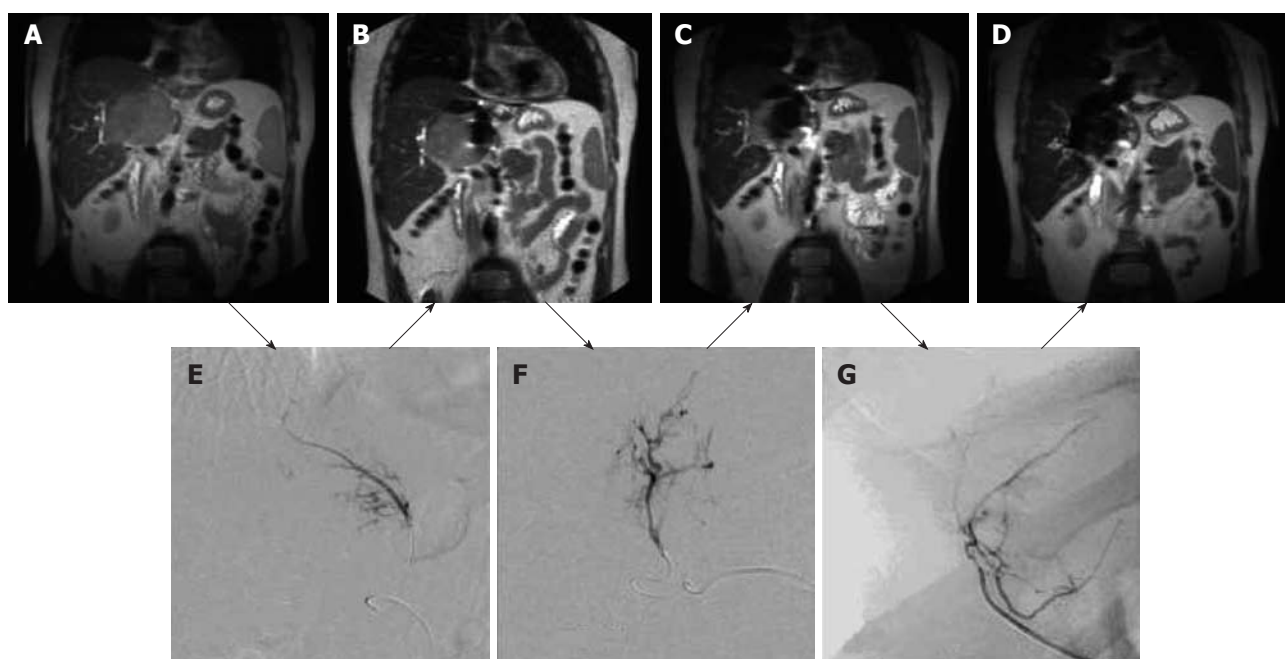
Coronal magnetic resonance images of large hepatocellular carcinoma obtained before magnetic targeted carrier bound to doxorubicin administration (A) and after the first (B), second (C) and third (D) dose of magnetic targeted carrier bound to doxorubicin. The selective hepatic arterial catheter was repositioned between each dose. The initial DSA image (E) was obtained during the injection of magnetic targeted carrier bound to doxorubicin (MTC-DOX) into the left hepatic artery supplying the tumor. The next dose was injected into the hepatic artery branch segment (F), while the third dose was injected into a branch of the right hepatic artery (G). As a result, progressively larger areas of the tumor were affected by MTC-DOX, as documented by the progressive loss of signal intensity due to iron susceptibility artifacts (T_2^*) on the intra-procedural coronal magnetic resonance images obtained after each injection.
